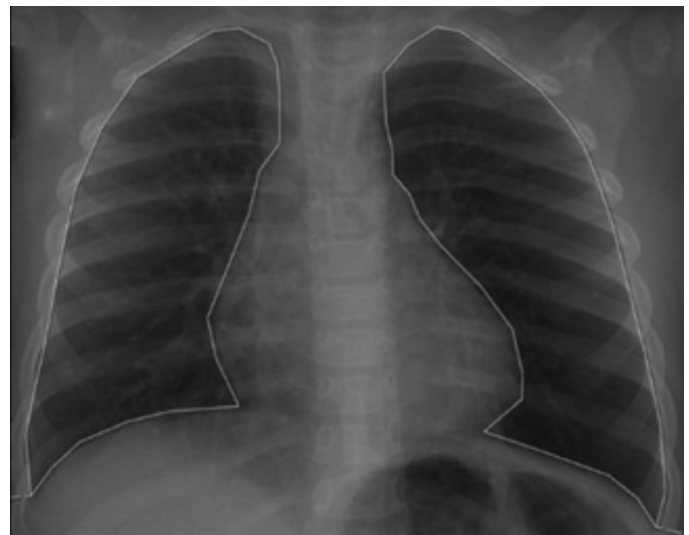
Chest X-ray showing lung regions of interest. The lung margin is delimited by the rib cage, cardiac border, and diaphragm
